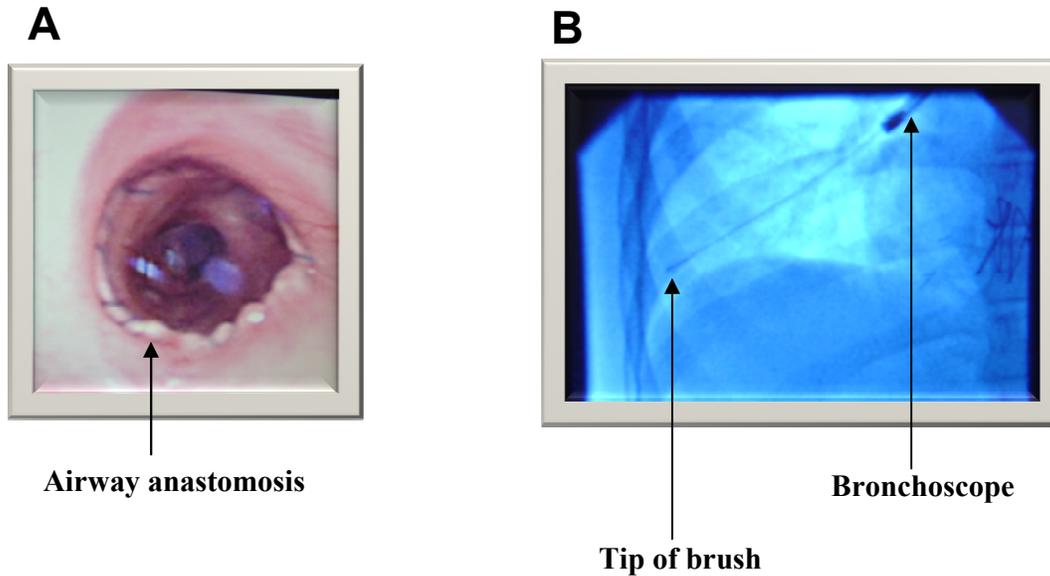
A - Bronchoscopic image of airway anastomosis (arrow) in a paediatric lung transplant recipient. B - Radiograph showing epithelial brushing from a peripheral airway under fluoroscopic control in a paediatric lung transplant recipient. Arrows point to tip of the flexible bronchoscope and tip of the brush (passed through the bronchoscopic channel) located in a peripheral airway of the right lung.
